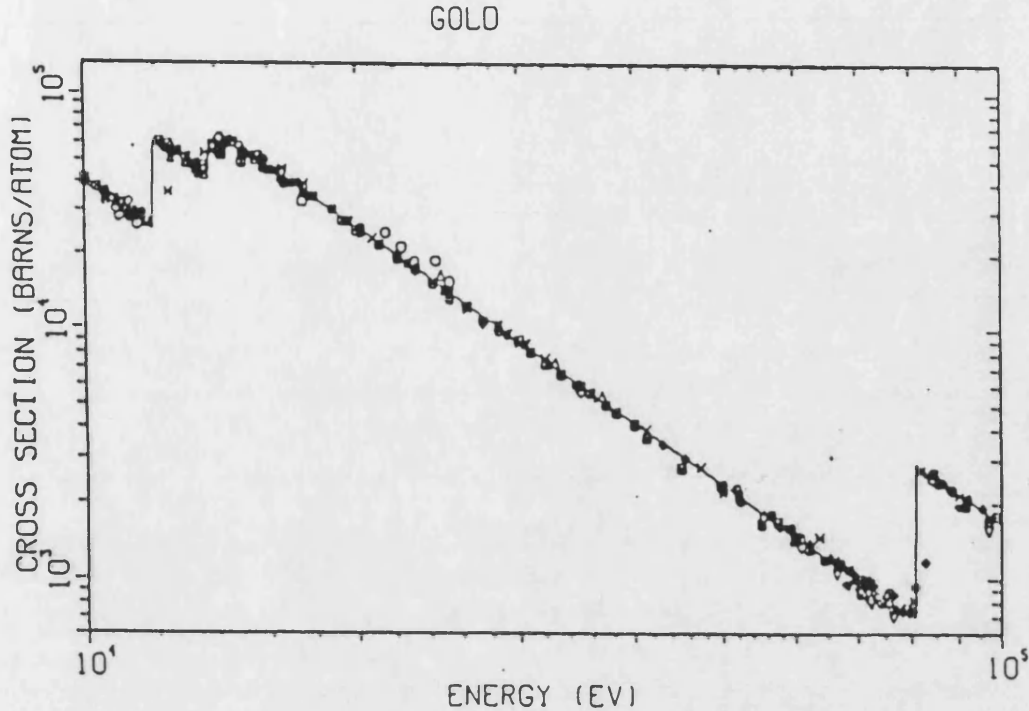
Total X-ray cross-section for gold (Z=79)
